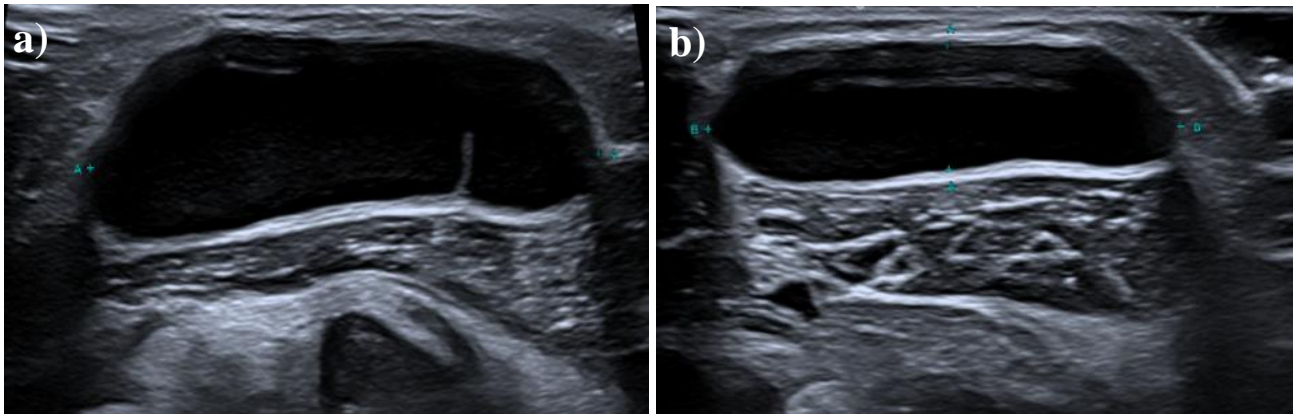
Axial (a) and sagittal (b) ultrasound images of pre-treatment of the Baker's cyst within the left popliteal fossa of the 11-month interval.
